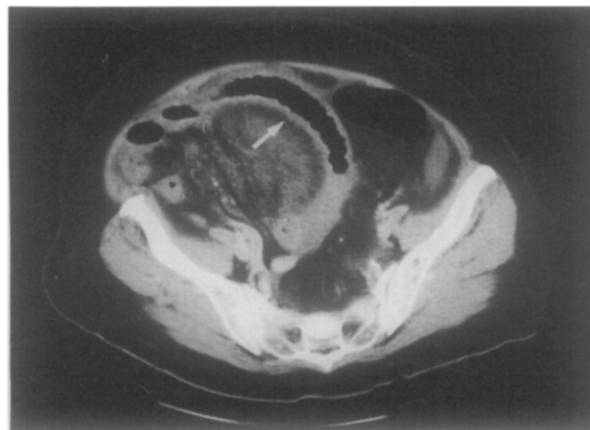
Abdominal computed tomography of patient with acute mesenteric venous thrombosis. Small bowel is distended, its walls thickened, and mesentery shows "streaking" and edema. *Arrow* shows thickened bowel wall.
